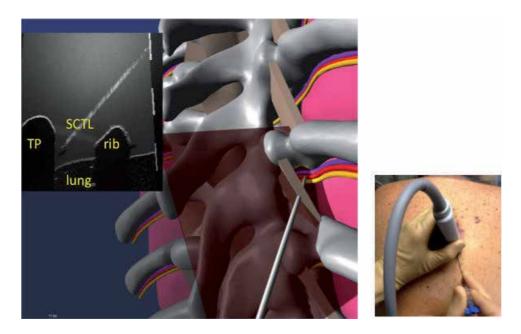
Live needle guidance for TPV block is an advanced technique and should be done only in individuals experienced in needle guidance under ultrasound. An oblique parasaggital view of the paravertebral space may improve visualization of the paravertebral space and pleura as well as an optimal needle trajectory.
